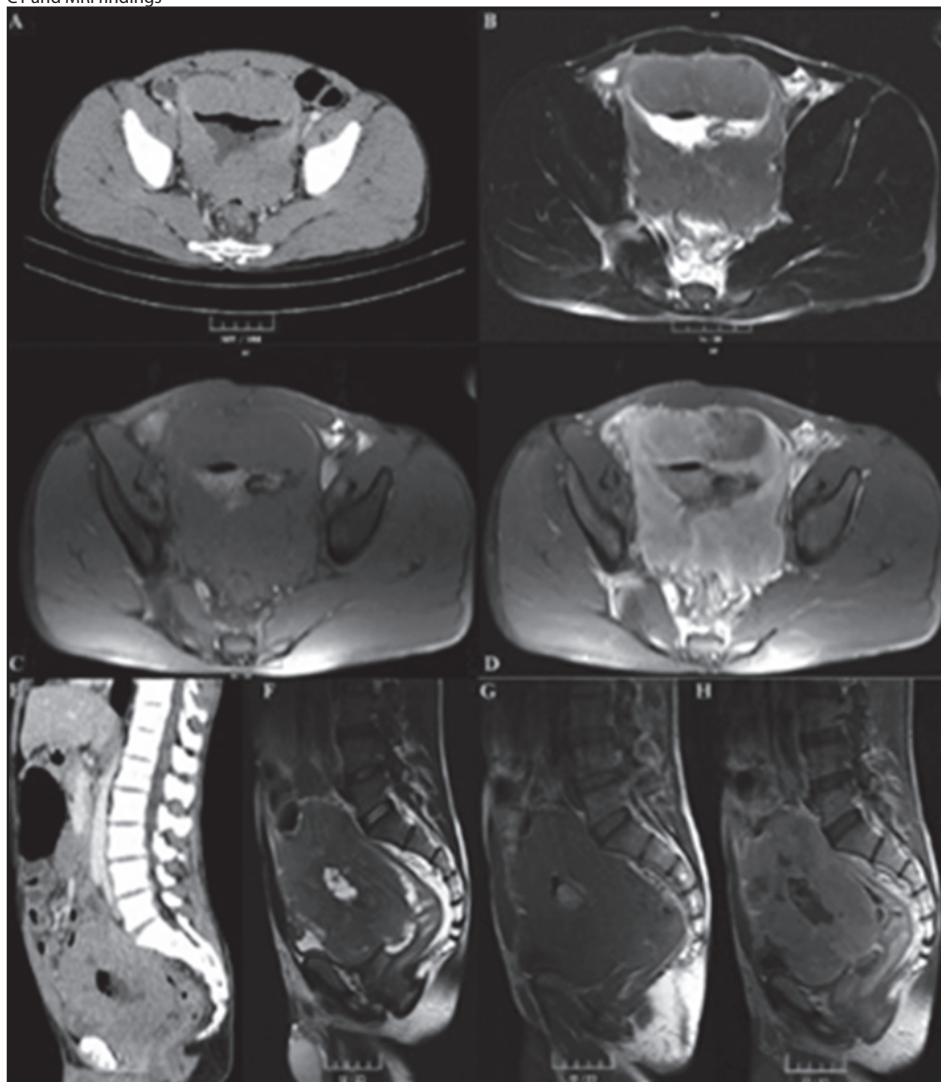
CT and MRI findings; A) Axial CT images revealed a soft tissue mass originated from anterior rectal wall and occupied the pelvic space. Lesion was associated with aneurysmatic segmental dilatations. B) T2 weighted MRI revealed diffuse, homogeneous thickening of anterior rectal wall. C-D) Non-contrast and iv. contrast administered T1 weighted MRI demonstrated the marked contrast enhancement of the mass. E) Sagittally reformed CT mages revealed giant soft tissue mass at the anterior border of rectum and growth in pelvic space. F) Sagittal T2 weighted MRI revealed iso-intense mass when compared with adjacent bowel walls was detected with central hyperintense compartment. G-H) Non-contrast and iv. Gadolinium administered T1 weighted MRI revealed the significant peripheral enhancement of the lesion with lack of associated lymphadenomegalies.
